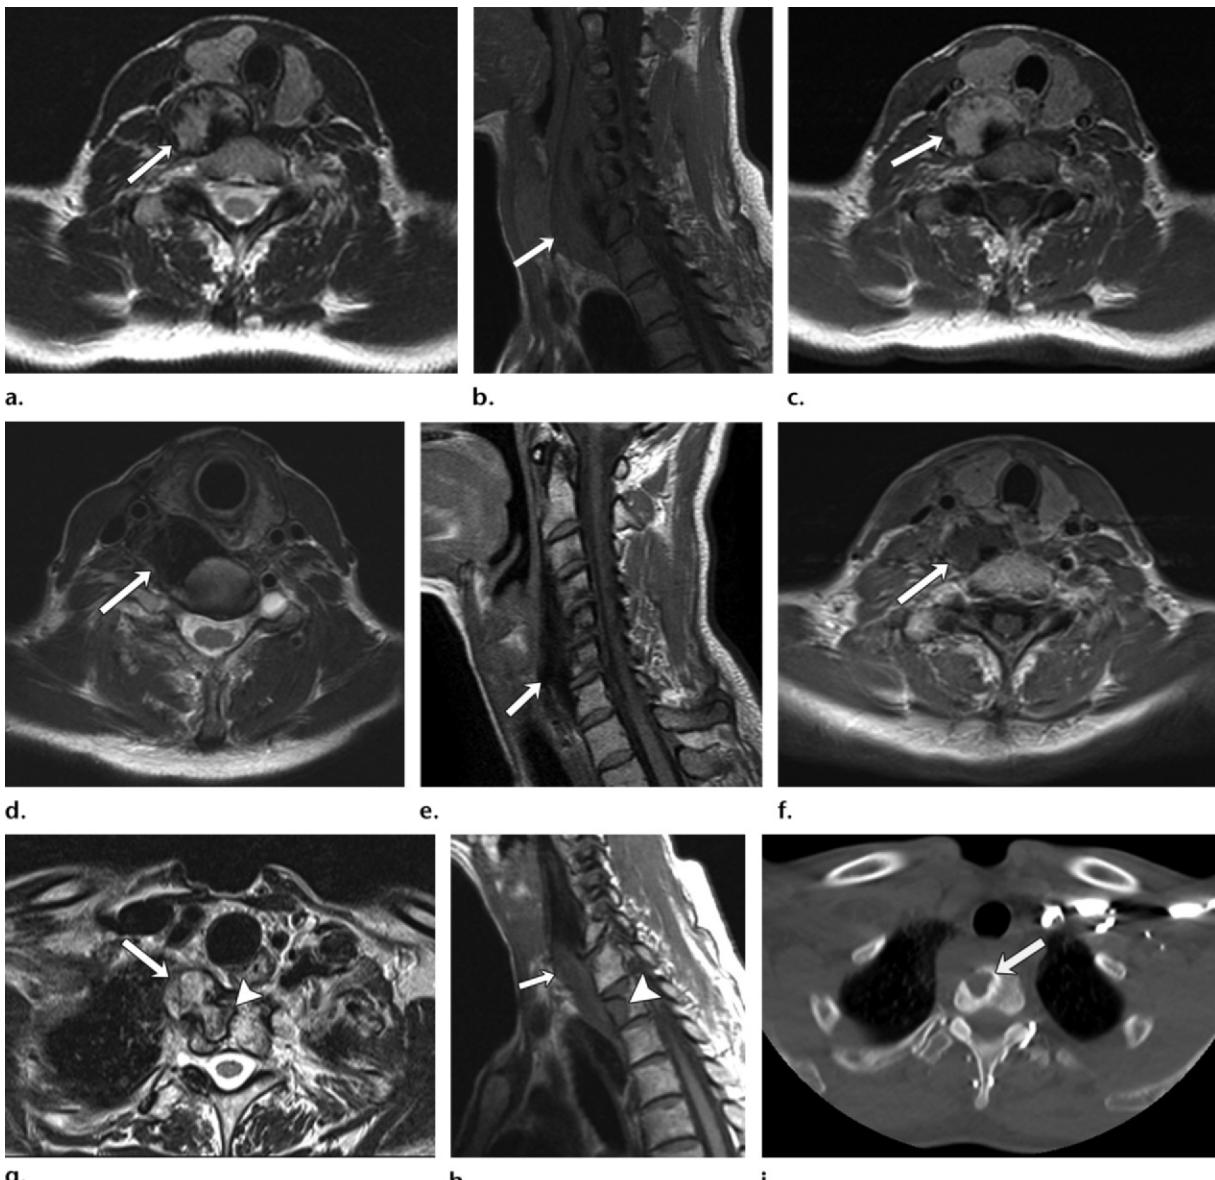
Positive response to RT of an unresectable extra-abdominal DF of the right neck in a 45-year-old woman, with subsequent locally aggressive disease. (a) Axial T2-weighted MR image (3100/98) shows a well-defined heterogeneously hyperintense right neck mass (arrow) posterior to the thyroid gland abutting the esophagus and the upper thoracic vertebral body. (b, c) Sagittal pre-contrast (b) and axial postcontrast (c) T1-weighted MR images (583/17) show a hypointense mass (arrow) with avid enhancement corresponding to the T2-hyperintense areas. (d–f) Axial T2-weighted (3800/80) (d), sagittal T1-weighted precontrast (550/15) (e), and axial T1-weighted postcontrast (530/14) (f) MR images, after RT, demonstrate slight decrease in tumor size but notable decrease (arrow in d, e) in signal intensity and decrease (arrow in f) in enhancement. (g, h) Axial T2-weighted (2900/106) (g) and sagittal T1-weighted (560/17) (h) MR images 7 years later demonstrate recurrent DF in the form of an increasing T2-hyperintense, T1-intermediate-signal-intensity component (arrow) along the inferior aspect of the main mass (arrowhead) with extension into the vertebral body. The superior component of the mass remains T1 hypointense. (i) Axial CT image (bone window) at the same level helps to confirm the osseous destruction (arrow).
